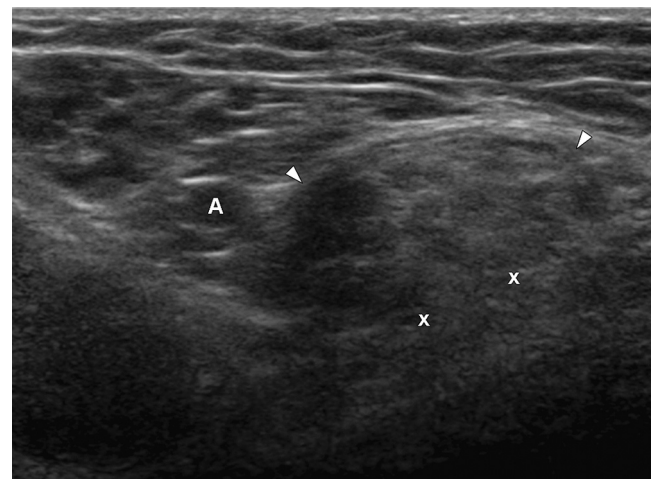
Femoral hernia. Transverse sonogram of the right groin below the inguinal ligament, showing a femoral hernia (arrowheads). The neck of the femoral hernia passes through the defect of femoral canal (marked by x). The femoral canal lies medial to the femoral artery, vein, and nerve. The hernia contains mesenteric fat. A = femoral artery.
